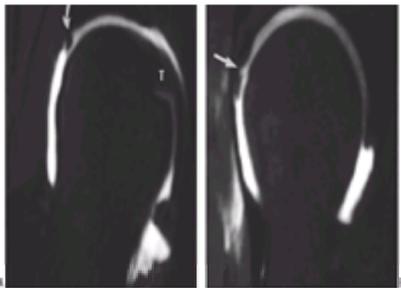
MR arthrography in a 25-year-old woman with hip dysplasia and hip pain. A: Coronal fat-suppressed, T1-weighted image after the intraarticular administration of gadolinium shows the ligamentum teres (T) and the transverse ligament. There is irregularity of the superior labrum (arrow). B: Oblique sagittal image of the same patient shows that the irregularity extends to the anterior labrum (arrow).
